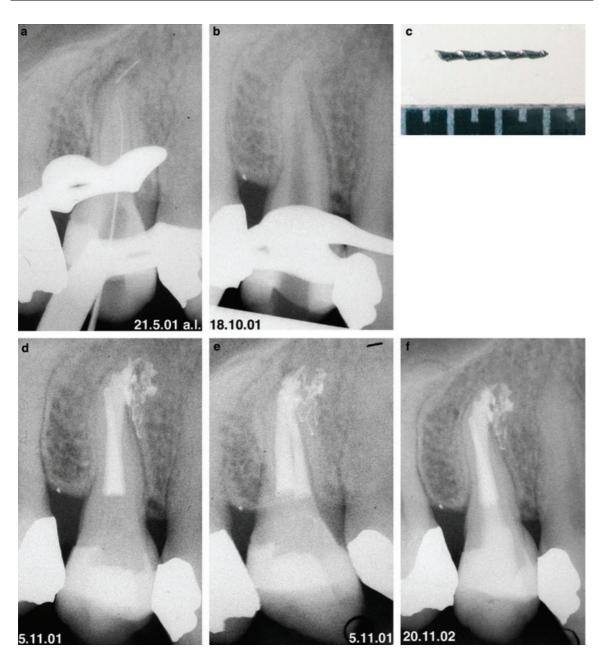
(a) Fractured size 20 H-File in the apical region of the palatal root canal of a maxillary right first premolar: patient was informed that the instrument could not be removed and that apical surgery would be necessary. (b) Surprisingly the instrument was removed after 60 min using an ultrasonically activated file; clinically no perforation could be detected. (c) Removed size 20 H-File. (d) Control radiograph after obturation: radiographically perforation cannot be excluded; nevertheless because of the study protocol, the case was judged as successful removal of a fractured instrument. (e) Control radiograph with eccentric projection after obturation. (f) 1 year recall: no clinical signs or symptoms.
